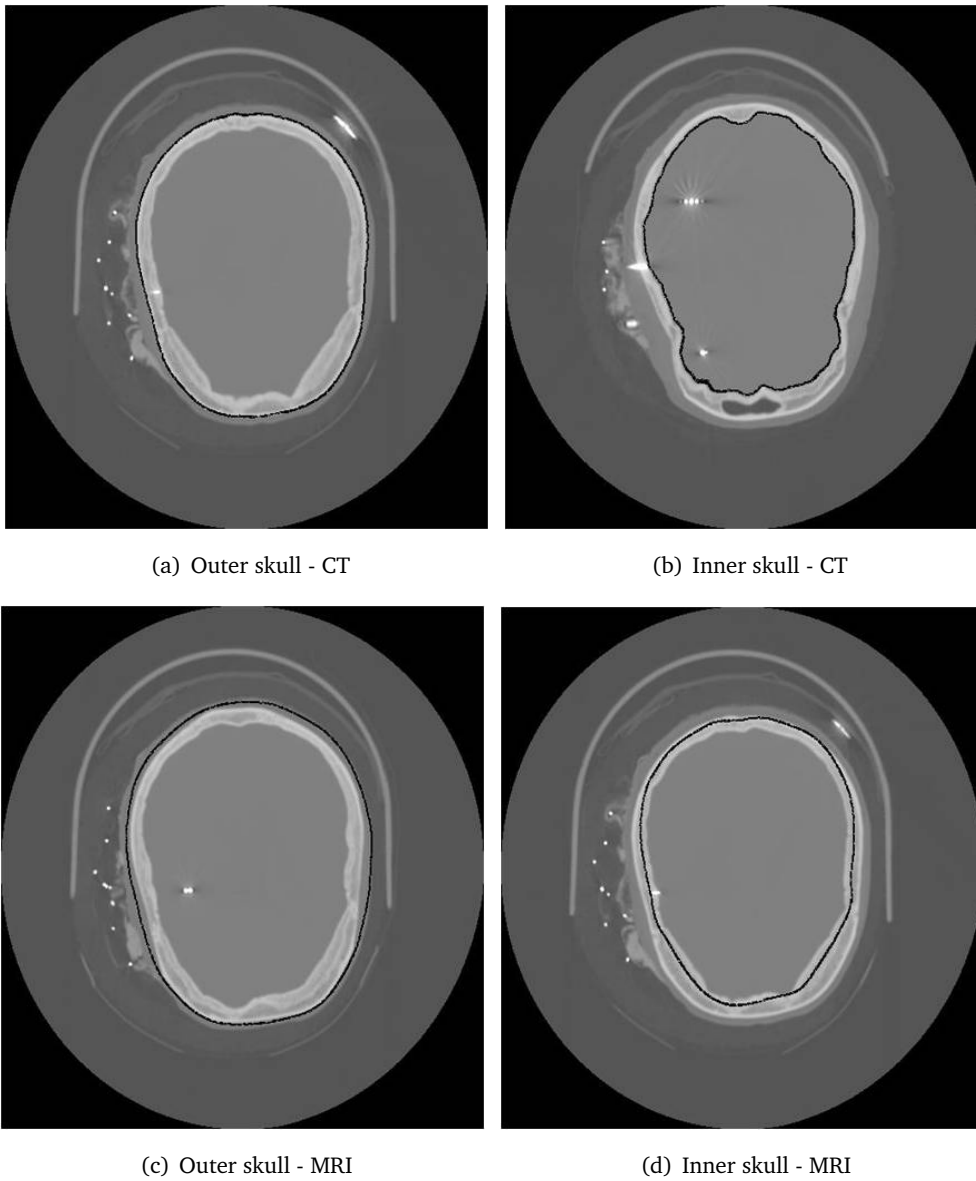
Segmentation of skull performed on MRI (using Freesurfer/MNE) and CT (using author's segmentation algorithm). Boundaries are interpolated onto the image as black lines. (a) Slice of CT together with the outer skull boundary as acquired by author's segmentation algorithm using the CT image. (b) Slice of CT together with the inner skull boundary as acquired by author's segmentation algorithm using the CT image. (c) Slice of CT together with the outer skull boundary as acquired by Freesurfer/MNE using the MRI image. (d) Slice of CT together with the inner skull boundary as acquired by Freesurfer/MNE using the MRI image.
